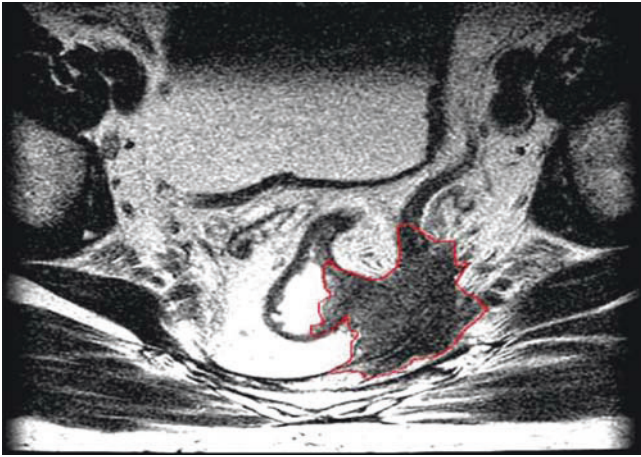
MRI of recurrent rectal cancer (*line*) showing lateral extension with tumor invasion of left pelvic side.
